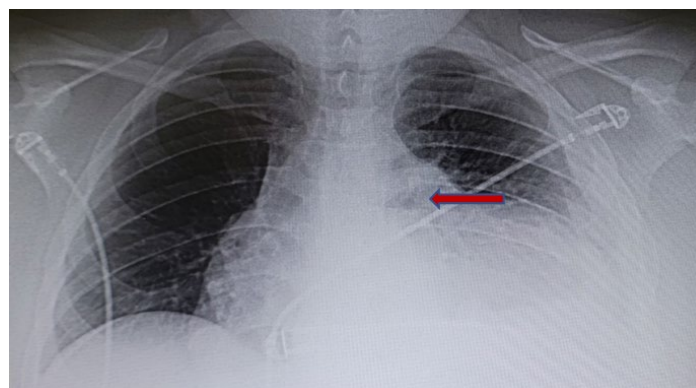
Chest x-ray showed cardiomegaly due to pericardial effusion.
